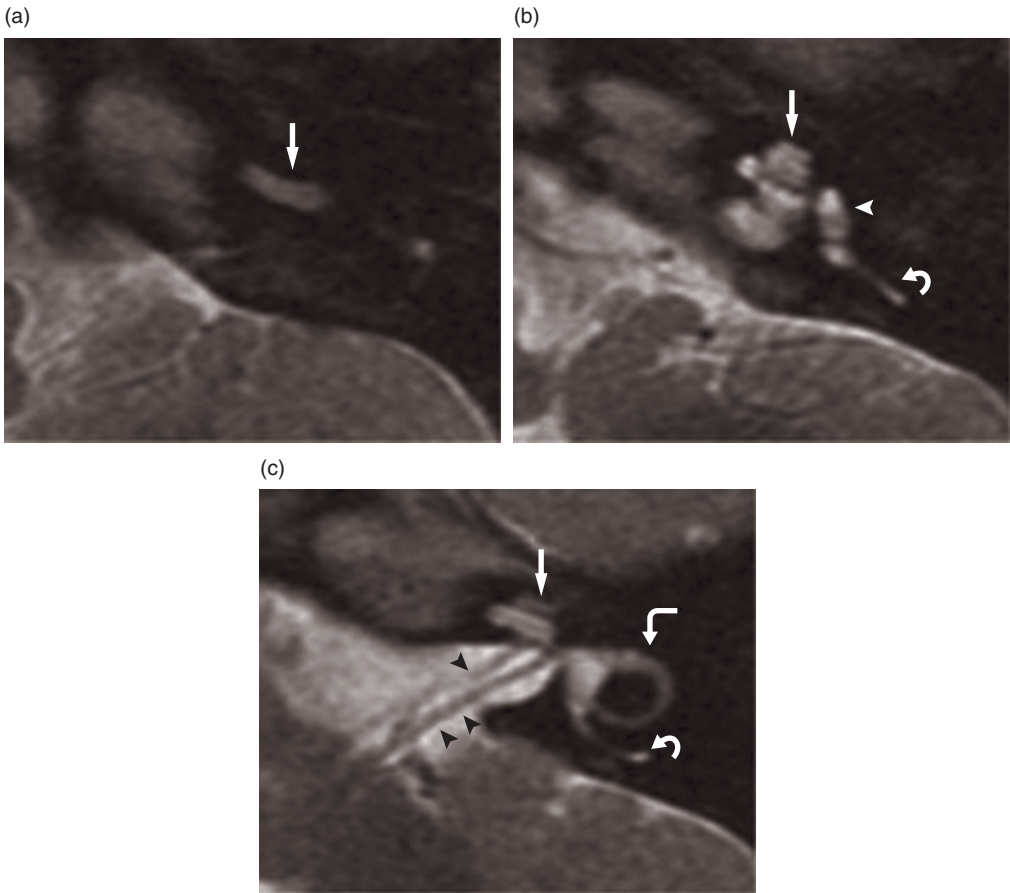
Axial T2-weighted MR images. (a) basal turn of the cochlea (arrow); b) cochlea (straight arrow), vestibule (arrowhead), posterior semicircular canal (curved arrow); c) cochlea (straight arrow), lateral semicircular canal (angled arrow), posterior semicircular canal (curved arrow), cochlear nerve (arrowhead), inferior vestibular nerve (double arrowhead).
